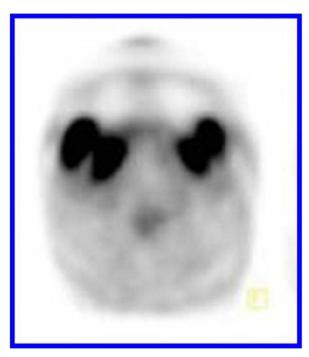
FDG uptake in masticatory muscles (pterygoid and masseter) in a patient who had been chewing gum.
